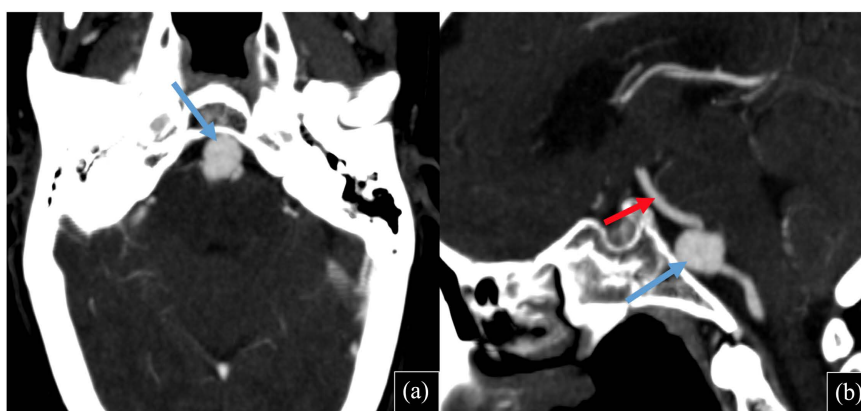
Cerebral CT angiography. Oblique axial section (a) and sagittal reconstruction (b) show a large unruptured saccular aneurysm (blue arrows) on the proximal portion of the basilar trunk (red arrow).
